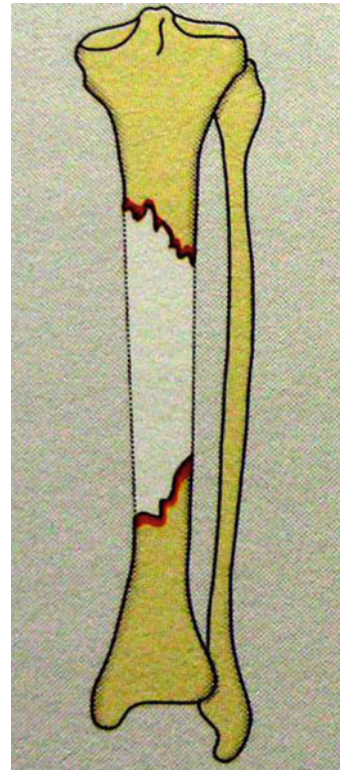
X-rays demonstrated a 15 cm segmental defect of the left tibia, multiple screw holes in both metaphyses, a 10° varus deformity, and an intact fibula
